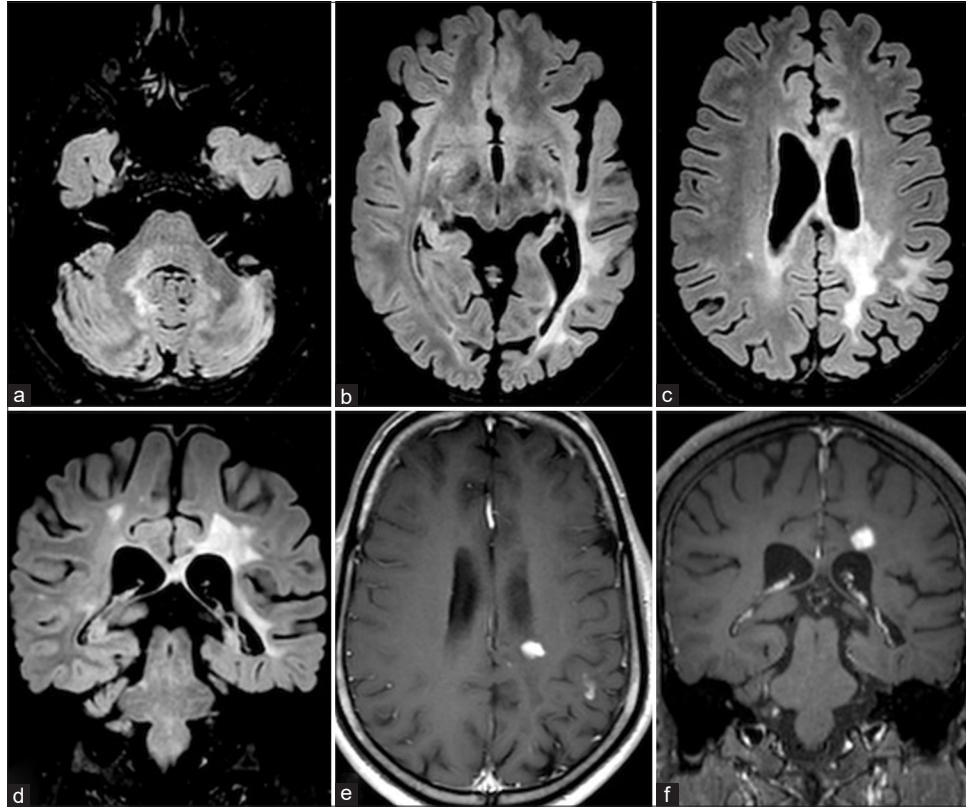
Magnetic resonance imaging images showing leukodystrophy like picture in a case of positive anti-myelin oligodendrocyte glycoprotein antibody – Axial (a-c) and coronal (d) FLAIR sections show multifocal confluent white matter hyperintensity in bilateral middle cerebellar peduncle (a), left cerebellar hemisphere (a), left peritrigonal white matter (b), and along periventricular and subcortical white matter of left posterior parietal lobe (c and d). Post-contrast axial (e) and coronal (f) sections show foci of nodular enhancement in the left parietal lobe.
